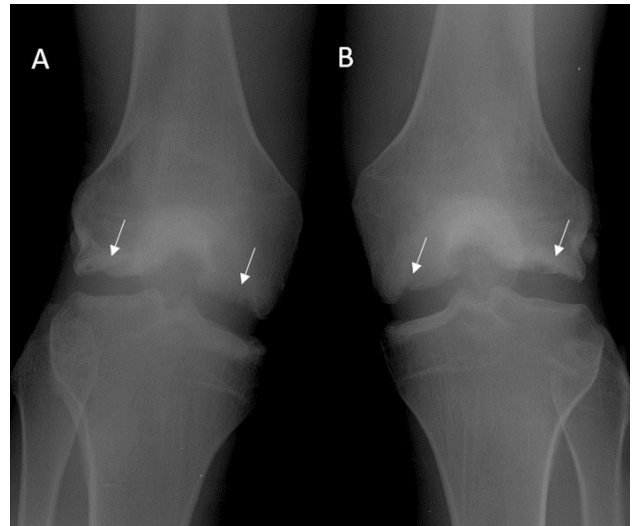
22-year-old male patient was admitted to the orthopedics clinic with pain in both knees. Anteroposterior radiographs of right (A) and left (B) knee which were performed to the patient as first imaging modality show lucency and irregularity (arrows) at lateral and medial femoral condyles bilaterally.
